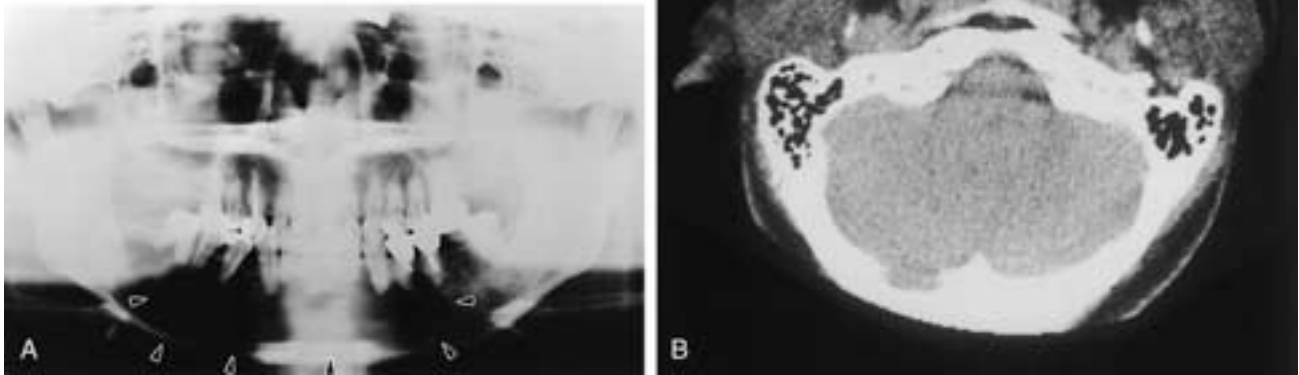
Mucoepidermoid tumor in the mandible. A, Pantomogram shows an ill-defined radiolucent lesion in the anterior part of the mandible (*arrowheads*). B, Axial CT of the mandible (soft-tissue window setting) demonstrates the ill-defined soft-tissue density lesion with multiple bony trabeculae. The surrounding buccal bony cortex is destroyed (*arrowheads*). (Courtesy of Dr. T. Kurabayashi, Dept. of Dental Radiology, Tokyo Medical and Dental University, Tokyo.)
